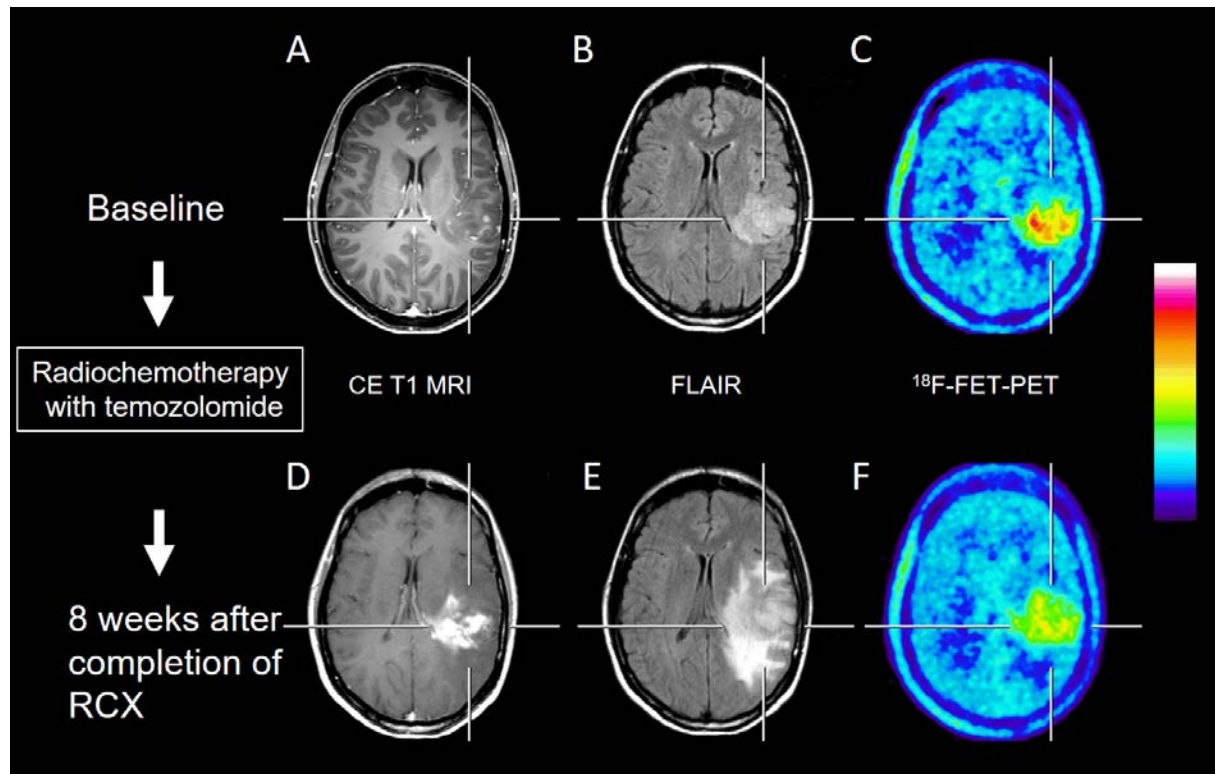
Therapy monitoring in a 47-year-old patient with glioblastoma. Contrast-enhanced MRI (CE T1 MRI), fluid-attenuated inversion recovery (FLAIR) MRI and FET PET (A-C) at baseline and 8 weeks after completion of chemoradiation with concomitant and adjuvant temozolomide (RCX)(D-F). Enlargement of contrast enhancement and FLAIR abnormalities suggest tumour progression whereas FET PET shows decreased metabolic activity compared to initial FET PET demonstrating pseudoprogression which was confirmed by follow-up MRI at 3 months after RCX.
